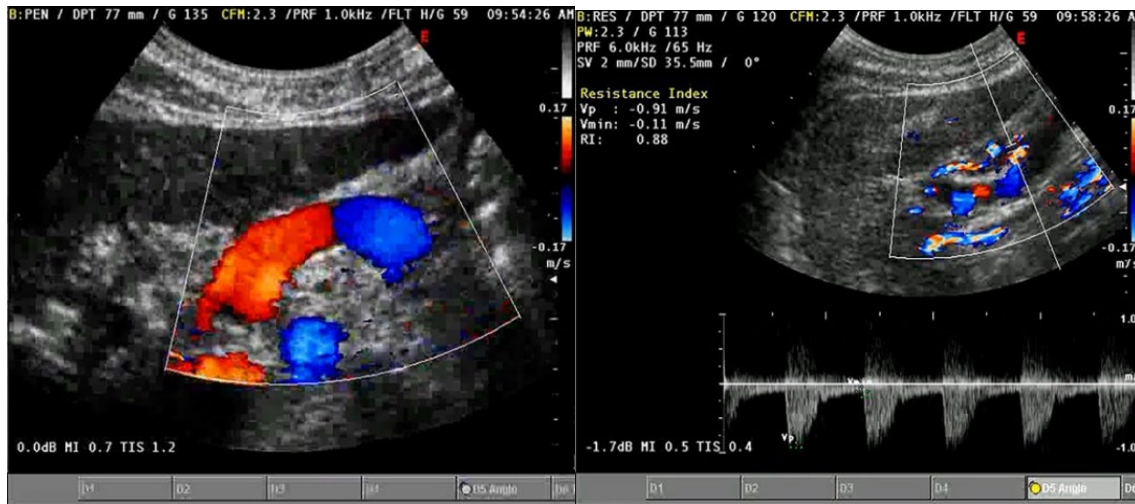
The Portal Vein can be examined via the right subcostal approach: the blue color in this scan indicates a hepatopetal flow (Figure 5a); the evaluation of the same vein with pulsed Doppler confirms a hepatopetal and still biphasic flow (Figure 5B); the Splenic Vein shows a double coloration of the flow on color Doppler (dependent on the direction of the flow relative to the vessel scanning point) but still demonstrates hepatopetal vascularization (Figure 5C); the pulsed Doppler study of the hepatic artery reveals a high resistance index (Figure 5D).
